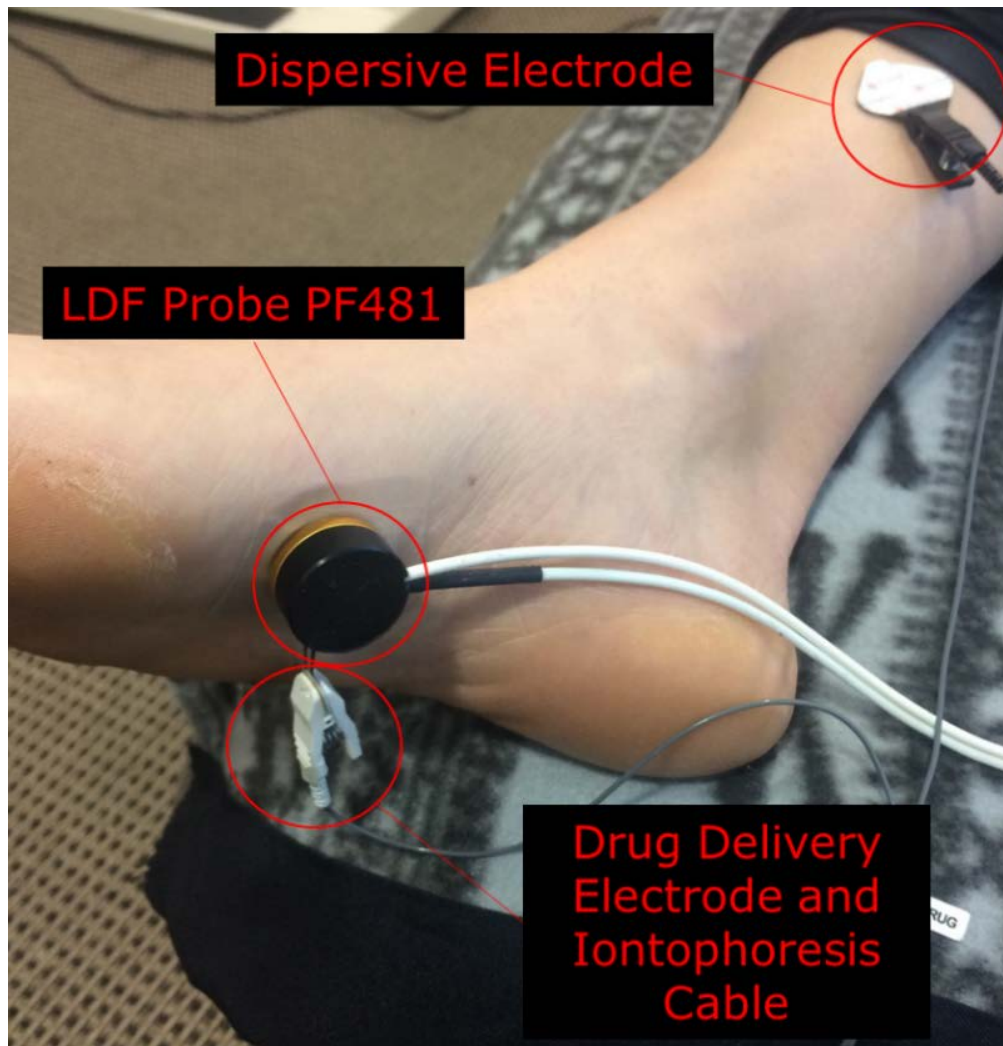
Laser Doppler Flowmetry and Iontophoresis Setup
